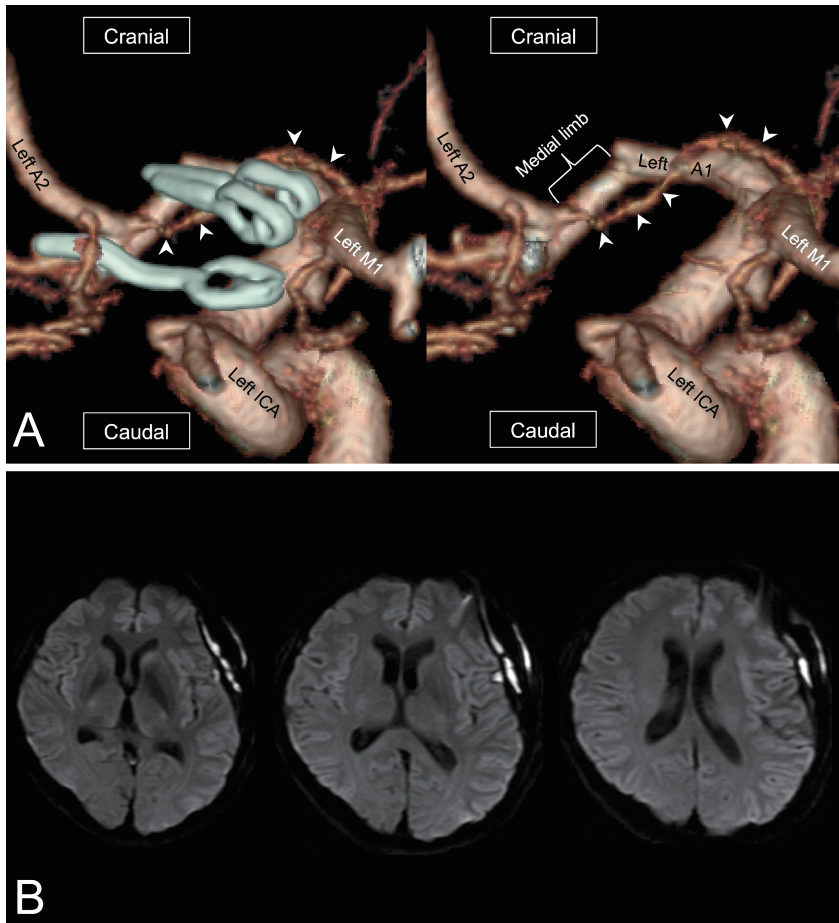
Postoperative three-dimensional rotational angiography (3D-RA) (A) and diffusion-weighted imaging (DWI) (B)
